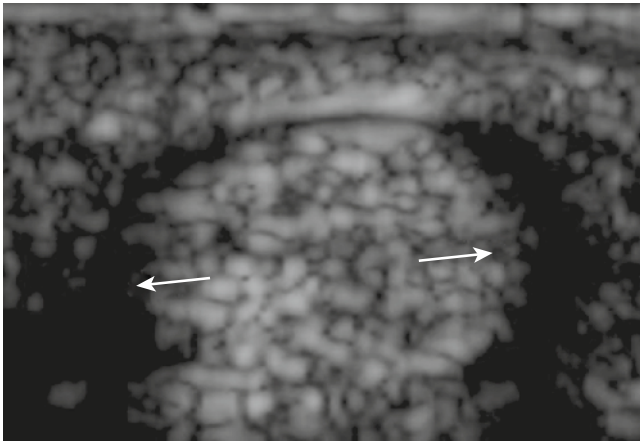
Edge shadowing artifacts (*arrows*) usually appear as narrow, hypoechoic, shadowy lines extending a significant distance distal to the lateral edges and parallel to the ultrasound beam.
